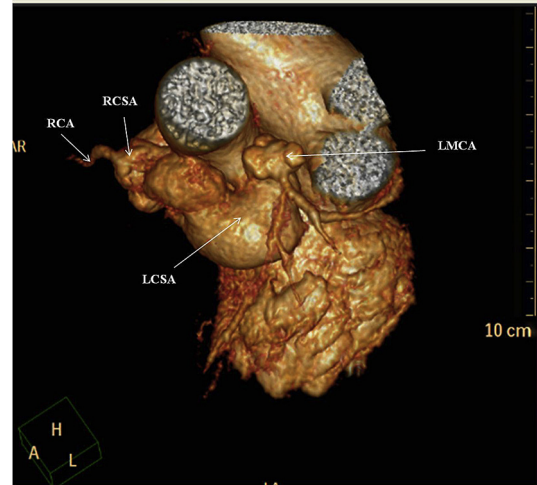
3D reconstructed CT angiography image of aorta. Both Left coronary artery and right coronary artery are arising from above the aneurysm. Note the dilatation of left main coronary artery (LMCA). RCSA – right coronary sinus aneurysm, LCSA – Left coronary sinus aneurysm, RCA – right coronary artery.
